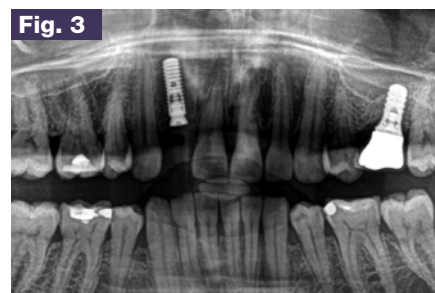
Control X-ray after insertion of OKTAGON® BL RC Ø 4.1 mm, L 12 mm
